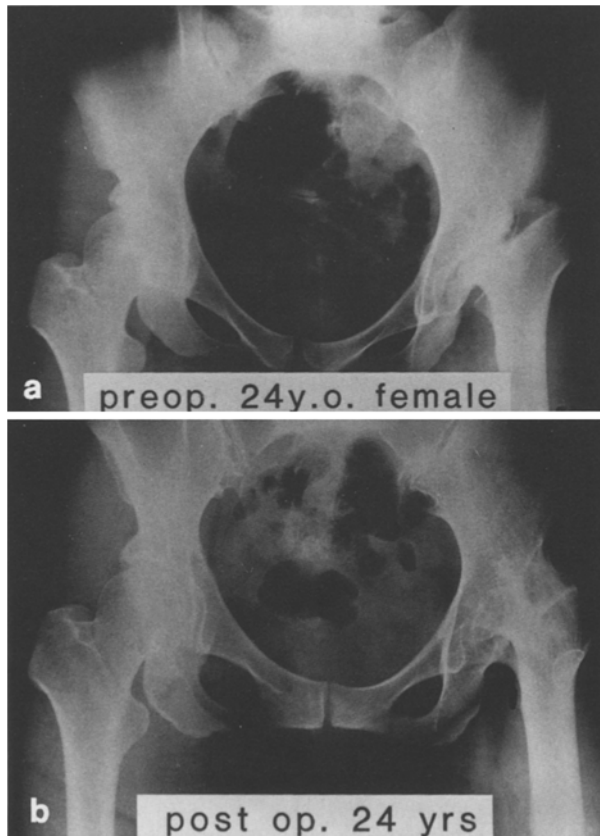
a Radiograph of the hips of a 24 year old woman before arthrodesis. b 24 years after operation. The opposite hip remains normal
